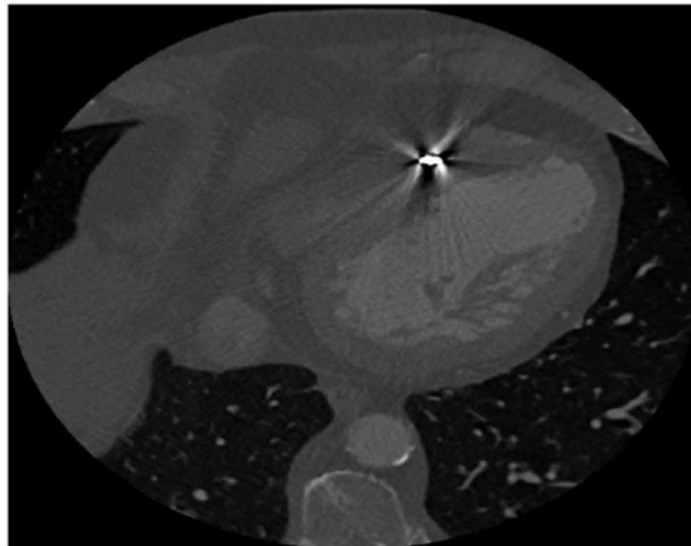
Slice of the CT scan showing the high radiodensity reflection from the pacemaker lead.
